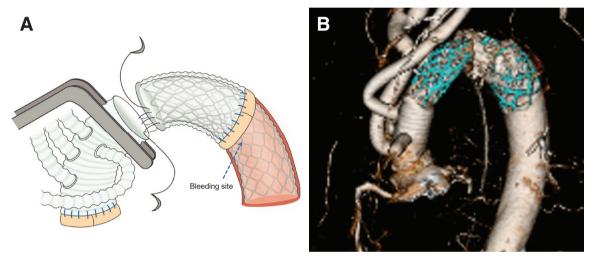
(A) Shema of the present method. (B) Postoperative 3-dimensional CT. CT: computed tomography
